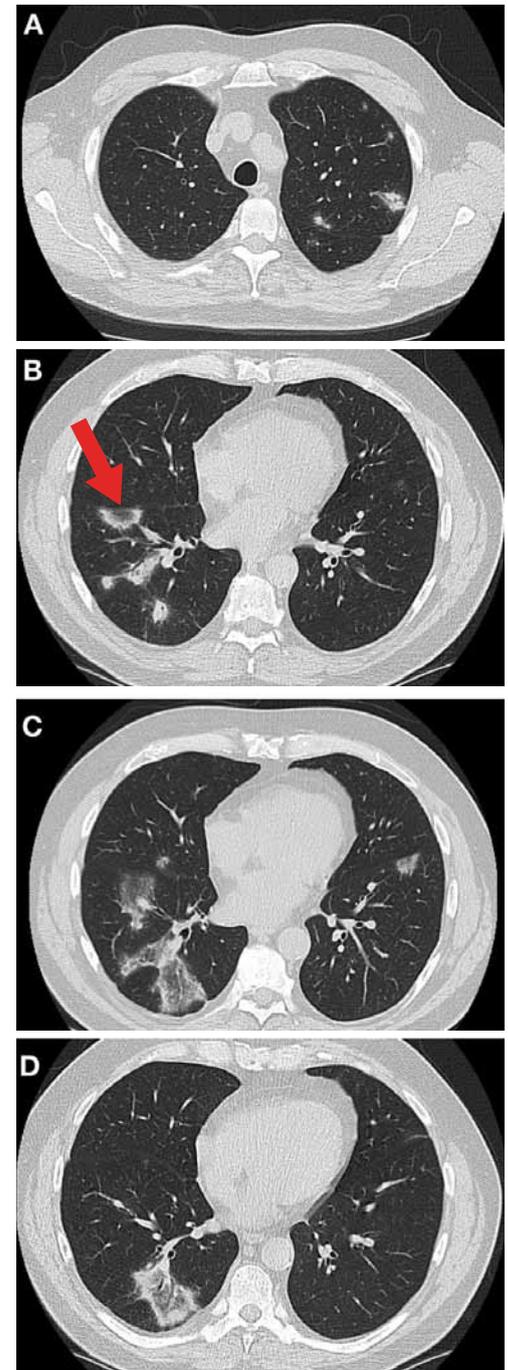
Transverse axial CT images from one study of the patient's chest from January 2018. Patchy airspace opacities can be seen in the left upper lobe (A) and airspace opacities within the right middle lobe and right lower lobe (B, C, and D). Many of these lesions have peripheral consolidation with central ground glass opacity (reversed halo/atoll sign; see arrow).
